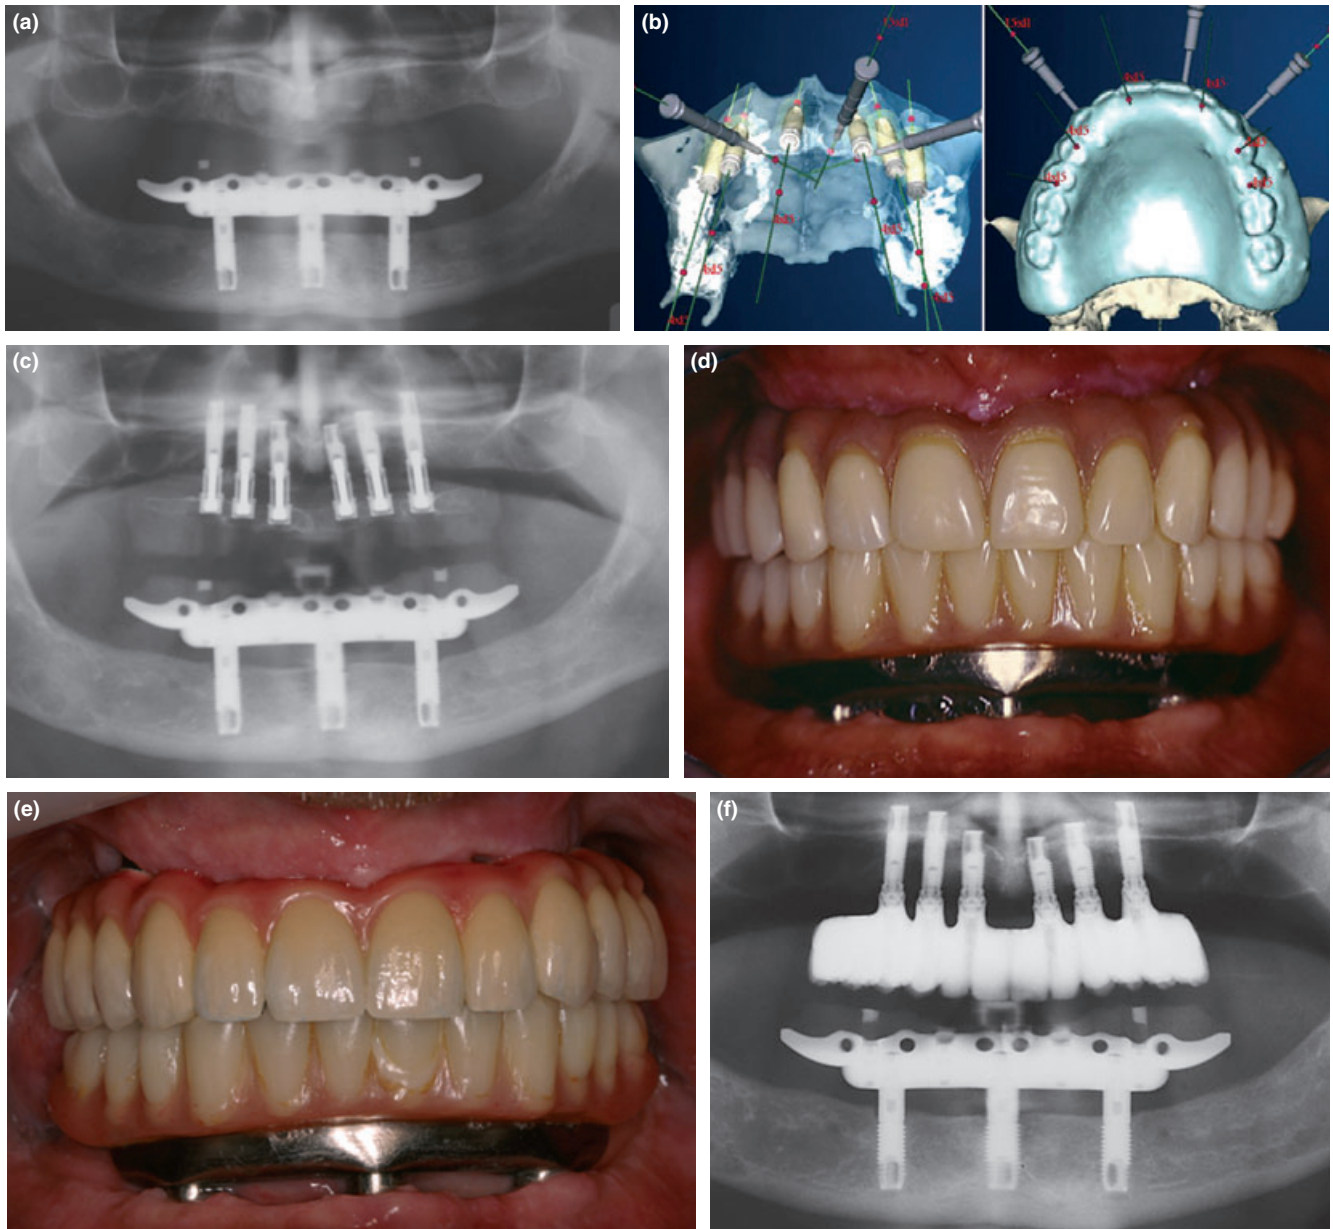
Patient 3. (a) Panoramic radiograph, postoperative view mandibular SDT using prefabricated componentry. (b) Guided surgery software planning maxilla. (c) Postoperative panoramic radiograph SVT maxilla with provisional prosthesis. (d) Postoperative clinical view, maxilla SVT provisional prosthesis. (e) Clinical view finalized prostheses, porcelain fused to metal fixed prostheses maxilla, hybrid titanium acrylic prosthesis, mandible. (f) Postoperative radiographic follow-up 4 years maxilla, 6 years mandible.
